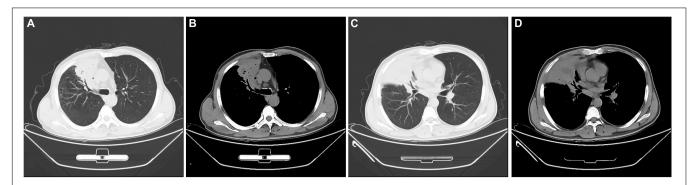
Chest computed tomography images at admission. A consolidation shadow in the right upper and middle lobes, with necrosis containing foci of air. (A,C) lung window; (B,D) mediastinal window.
